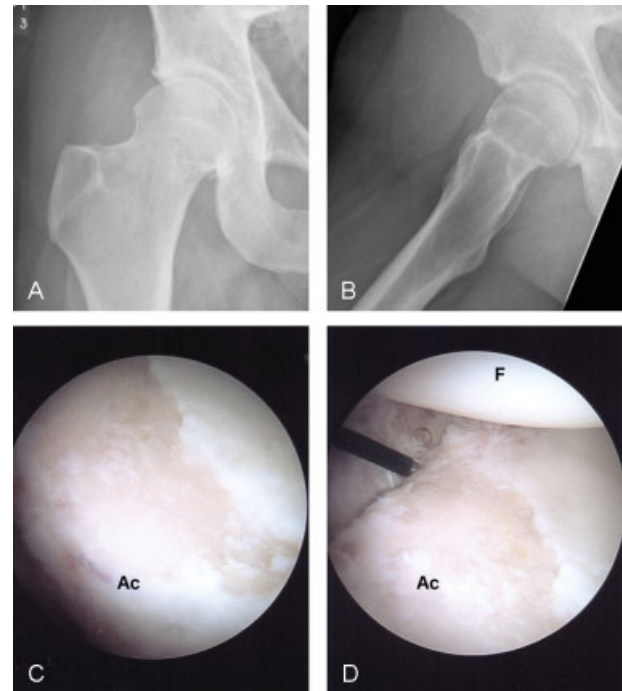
Hip Arthroscopy demonstrates the preoperative radiographs (A,B) and intraoperative arthroscopy images (C,D) of patient 8. This 26 year-old man underwent right hip arthroscopy, labral and chondral surface debridement, and removal of loose bodies. The joint space width in (A) was measured to be 4.3 mm. However, during arthroscopy, the patient was noted to have grade 4 changes of the acetabular cartilage (C). Notice in (D) that the patient's femoral head cartilage is pristine, which likely accounts for why this patient has ample joint space width on radiographs despite high-grade cartilage changes intraoperatively. Ac, Acetabulum; F, femoral head. (Radiographs and pictures courtesy of Dr. Ramin R. Tabaddor.)
